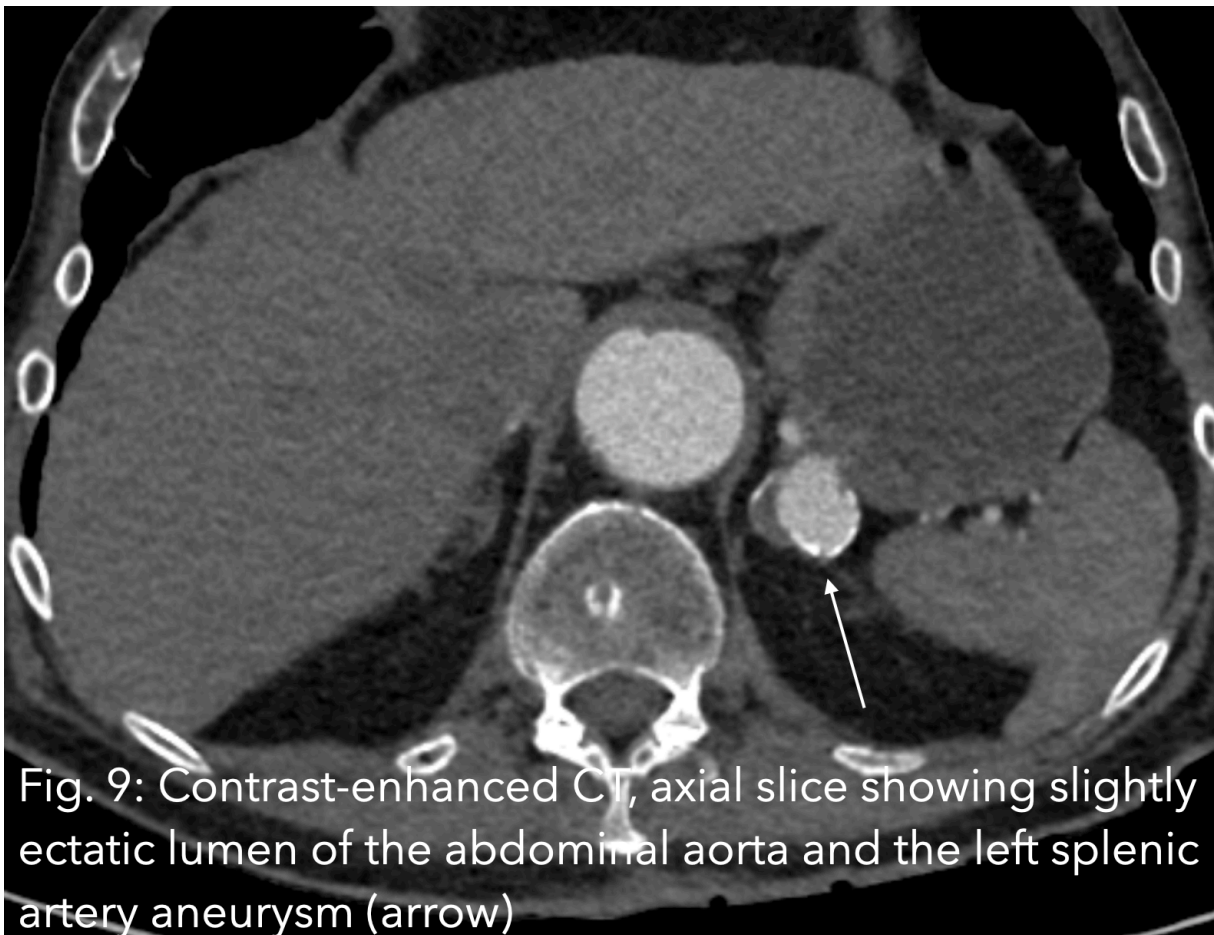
Contrast-enhanced CT, axial slice showing slightly ectatic lumen of the abdominal aorta and the left splenic artery aneurysm (arrow)
